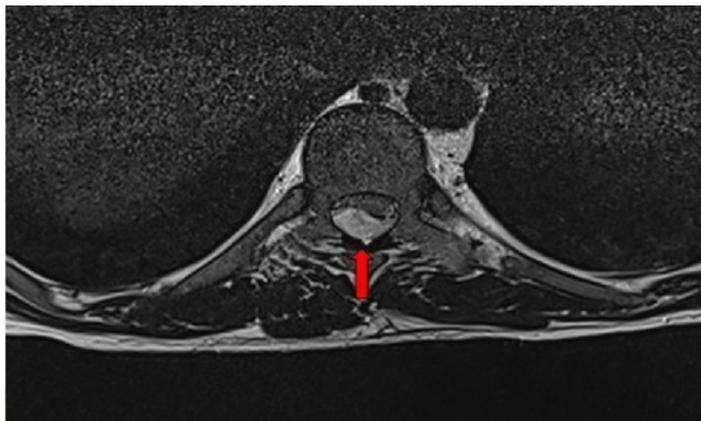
Axial view T2 weighted of MRI thoracic shows intraspinal extradural lesion at T8 - T10 level suggestive of hematoma and compressing the cord (red arrow).
